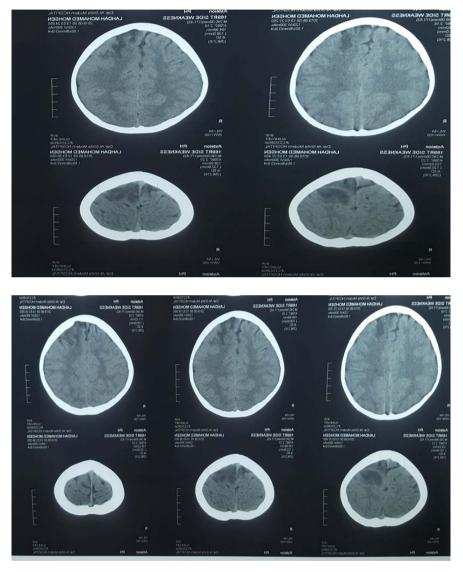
Brian CT scan; watershed infarction lesion in the left fronto-parietal region.
